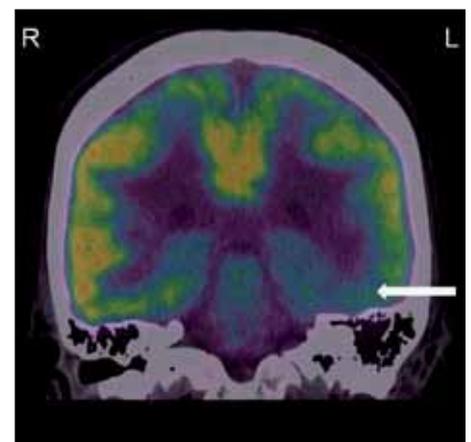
Magnetic resonance image-negative temporal lobe epilepsy in a 17-year-old male
